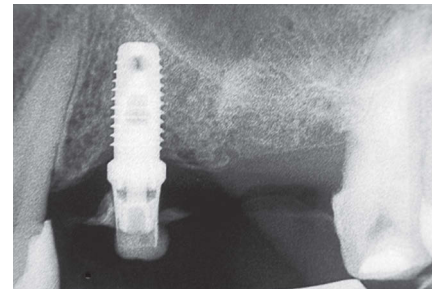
Radiograph showing healing six months after failure in implant #26 and the presence of machined implant surface of #24.
